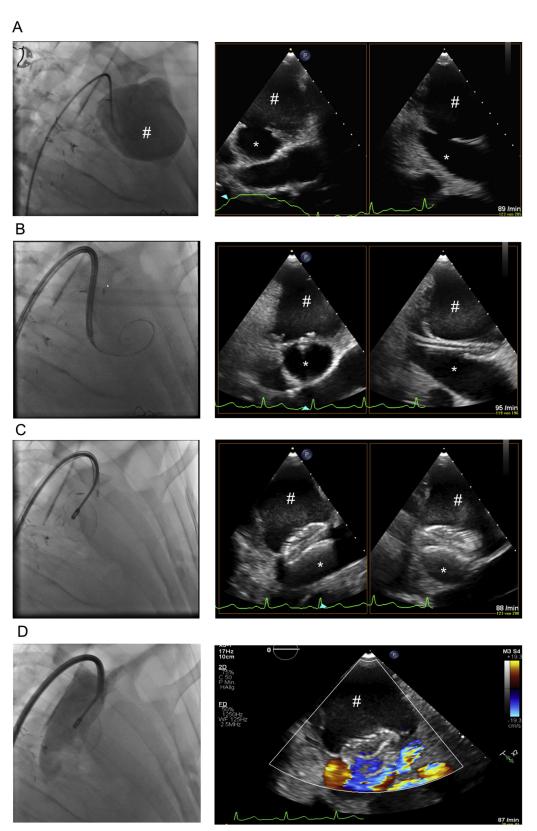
Transfemoral closure of the pseudoaneurysm using an Figulla Flex II ASD occluder. The left-side pictures show fluoroscopic images, and the right-side pictures show echocardiographic pictures of a suprasternal view. (A) (*Left*) cannulation and depiction of the pseudoaneurysm using a right JR4; (*right*) biplane echocardiographic depiction of the pseudoaneurysm including the anuerysmal neck. (B) Introduction of an Occlutech delivery sheath into the pseudoaneurysm over a pigtailed Amplatz stiff wire. (C) Successful implantation of an ASD Figulla Flex II occluder. (D) Complete exclusion of the aneurysm from the circulation. The *asterisk* (*) shows the ascending aorta, and the *pound sign* (#) shows the pseudoaneurysm.
